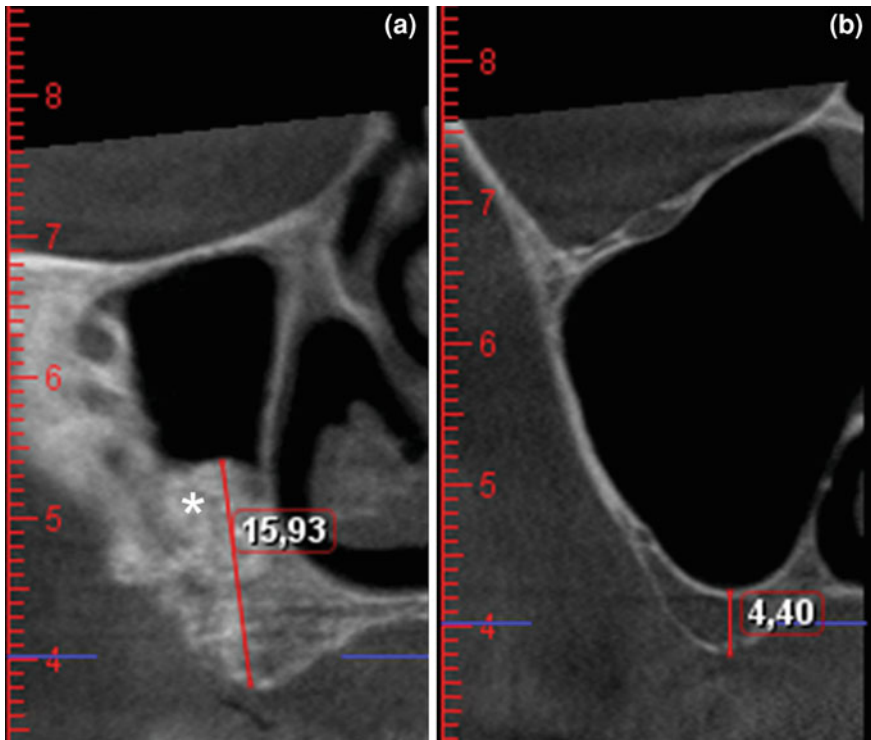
CBCT cross-sections showing measurement of the distance between the floor of the right maxillary sinus and the alveolar crest in the molar region (b) and at level of bone graft (*) (a)
